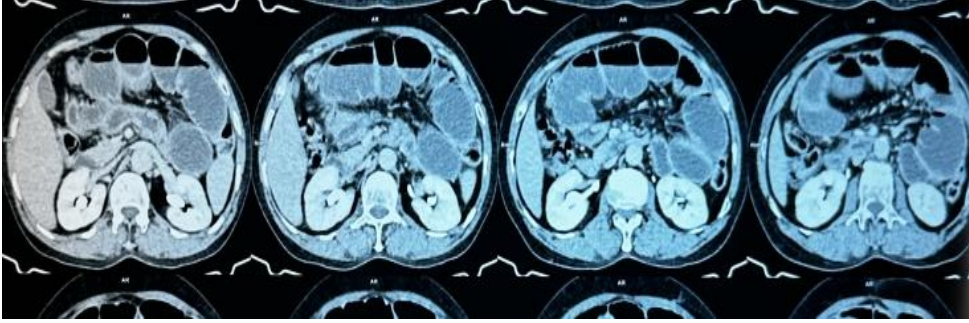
Showing the similar findings in axial section of CT abdomen and pelvis
